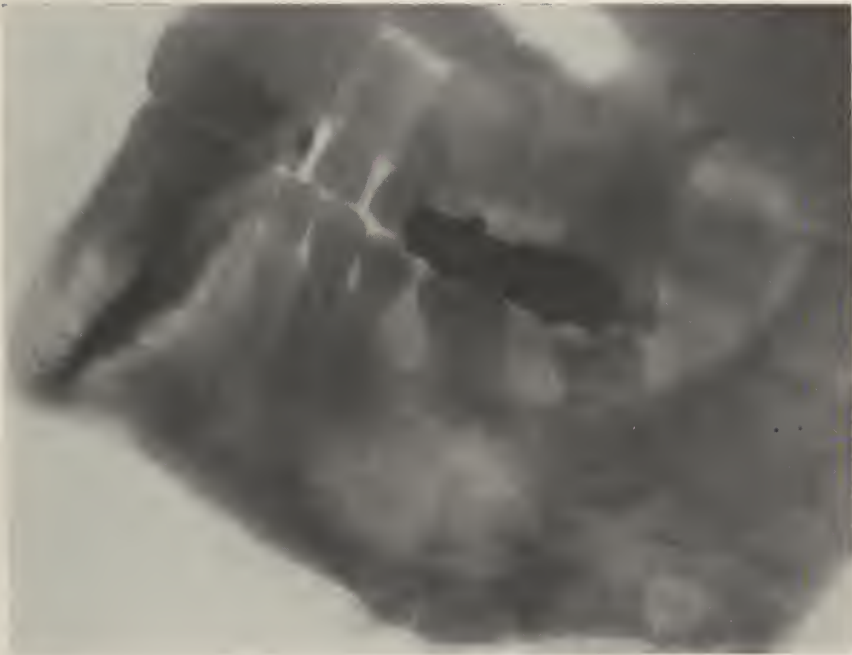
Chronic suppurative osteitis in a man 28 years of age. The infection followed a traumatic injury although there was no fracture. Wassermann test was negative and there were no symptoms of tuberculosis. Note the diffused bone destruction and the subperiosteal enlargement of the bone at the point of lesion. Radiograph was taken when he was first seen, two months after the injury was sustained.
